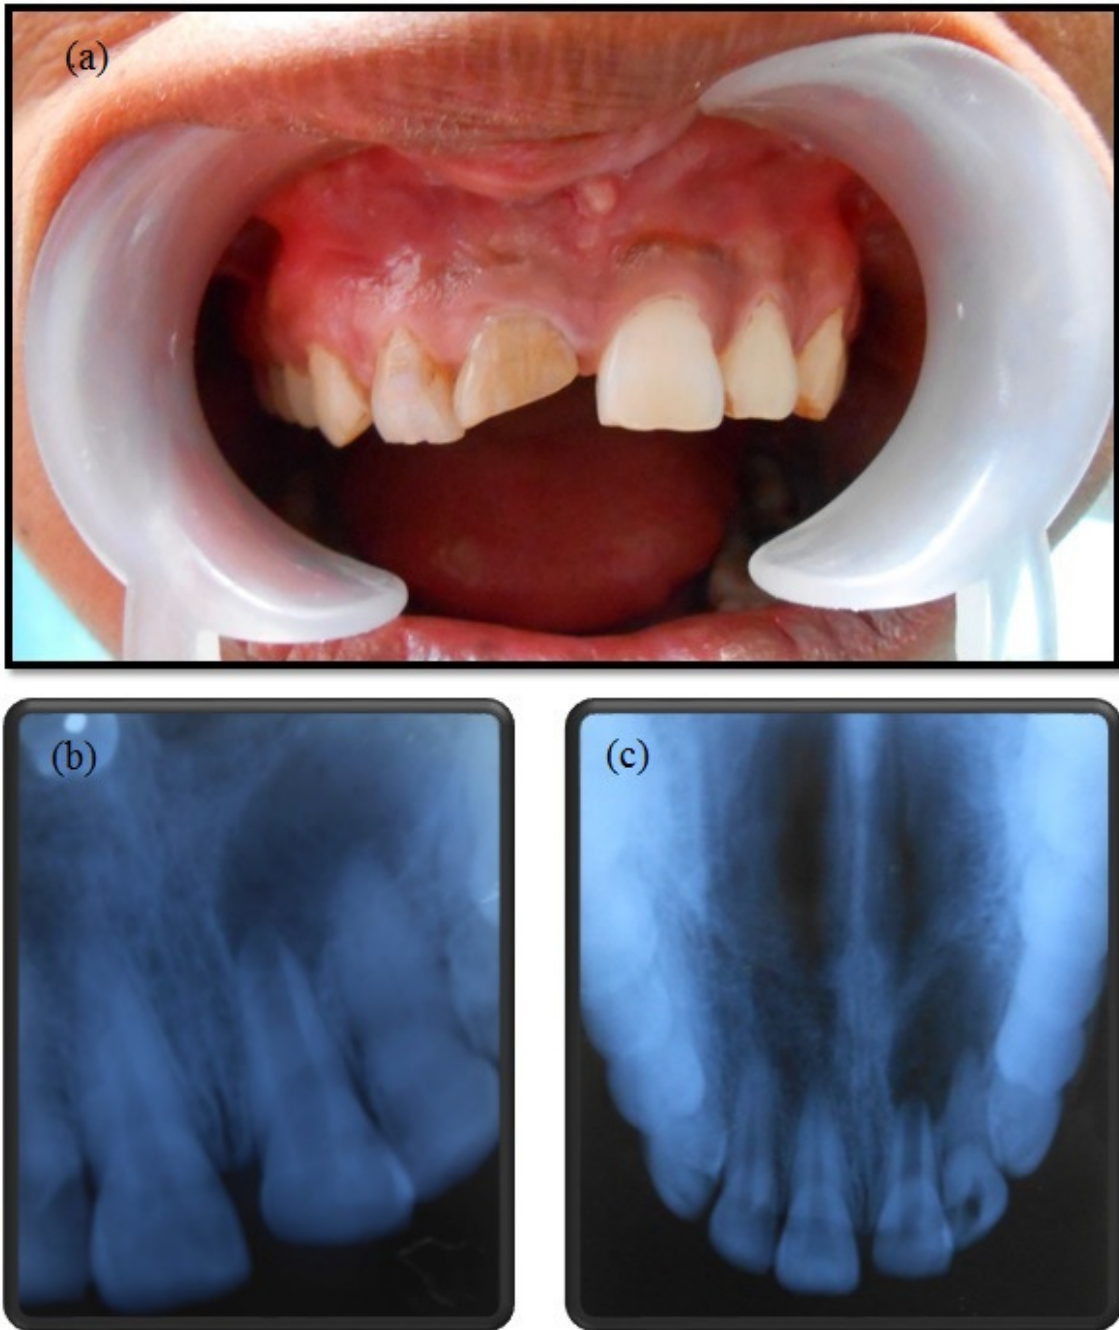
Pre-operative views of case a) clinical view showing discoloured and fractured right maxillary central incisor, b) Intra-oral periapical (IOPA) radiograph, c) occlusal view showing radiolucency in relation to right maxillary central, lateral incisors and calcified canal of lateral incisor
